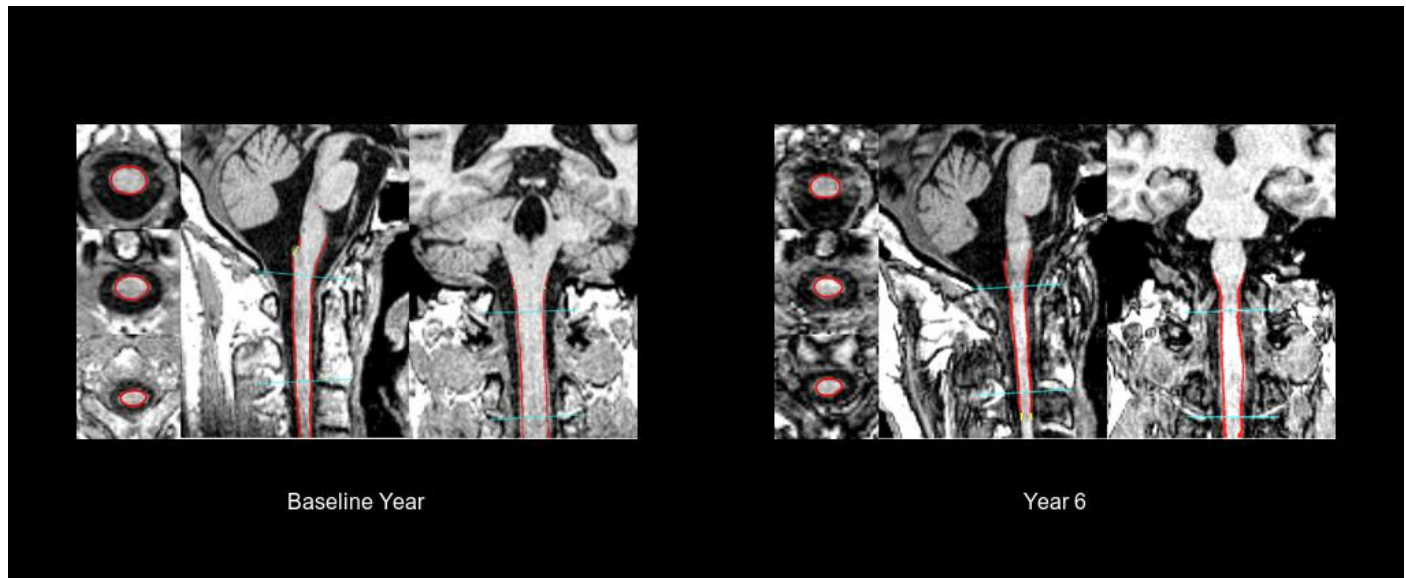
Segmented MR imaging of one representative PPMS patient at baseline and 6 years after. Notice the significant diffuse spinal cord volume loss in all three planes of the patient's images.*
